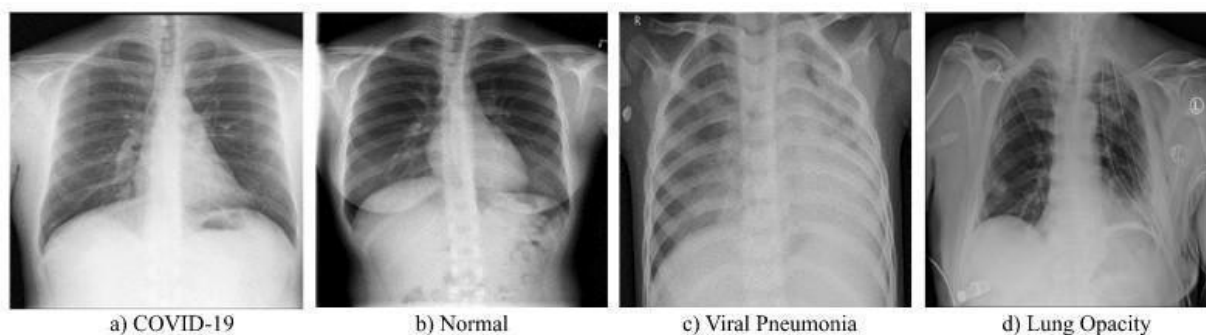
Images of chest x-ray are chosen as samples from the dataset (a) C-19 (b) N (c) VP (d) LO.
